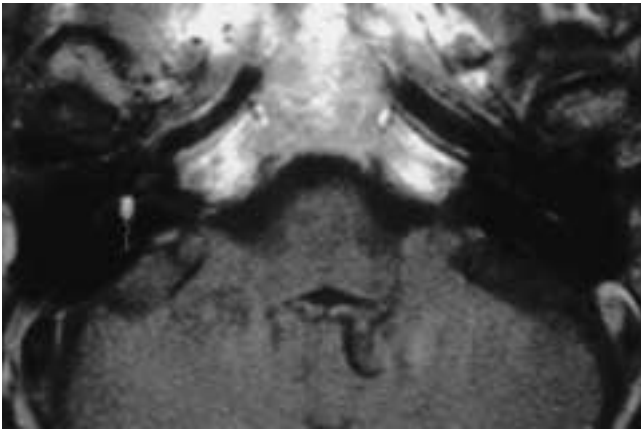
Intralabyrinthine hemorrhage. There is a region of hypersignal within the vestibule on these noncontrast T1-weighted images (arrow).
